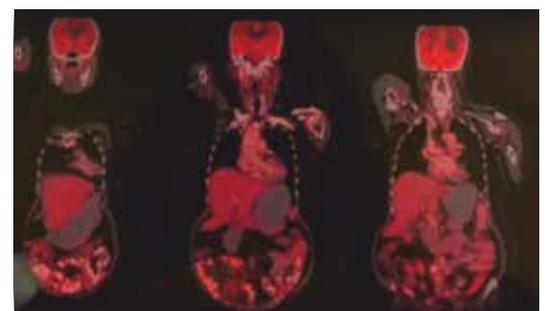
Follow up PET CT scan showing no evidence of disease
